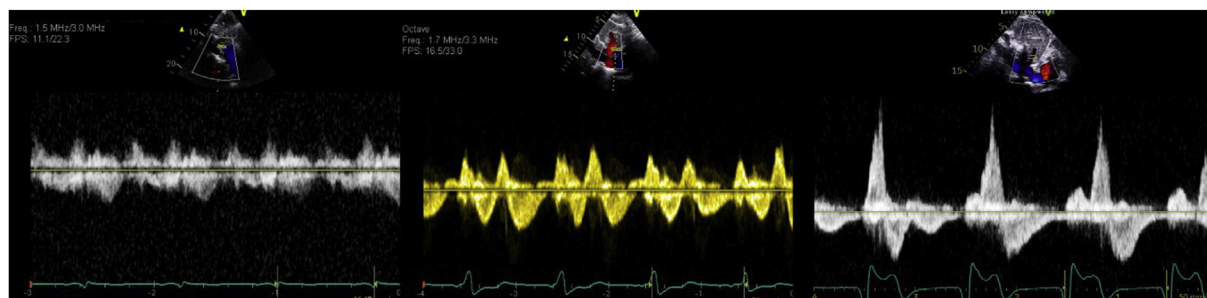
From left to right, image 1 shows no evident systolic flow reversal in the hepatic veins prior to LP implant; images 2 and 3 shows systolic reversal after LP implant on subsequent transthoracic echocardiograms done in 2019 and 2021, respectively.
